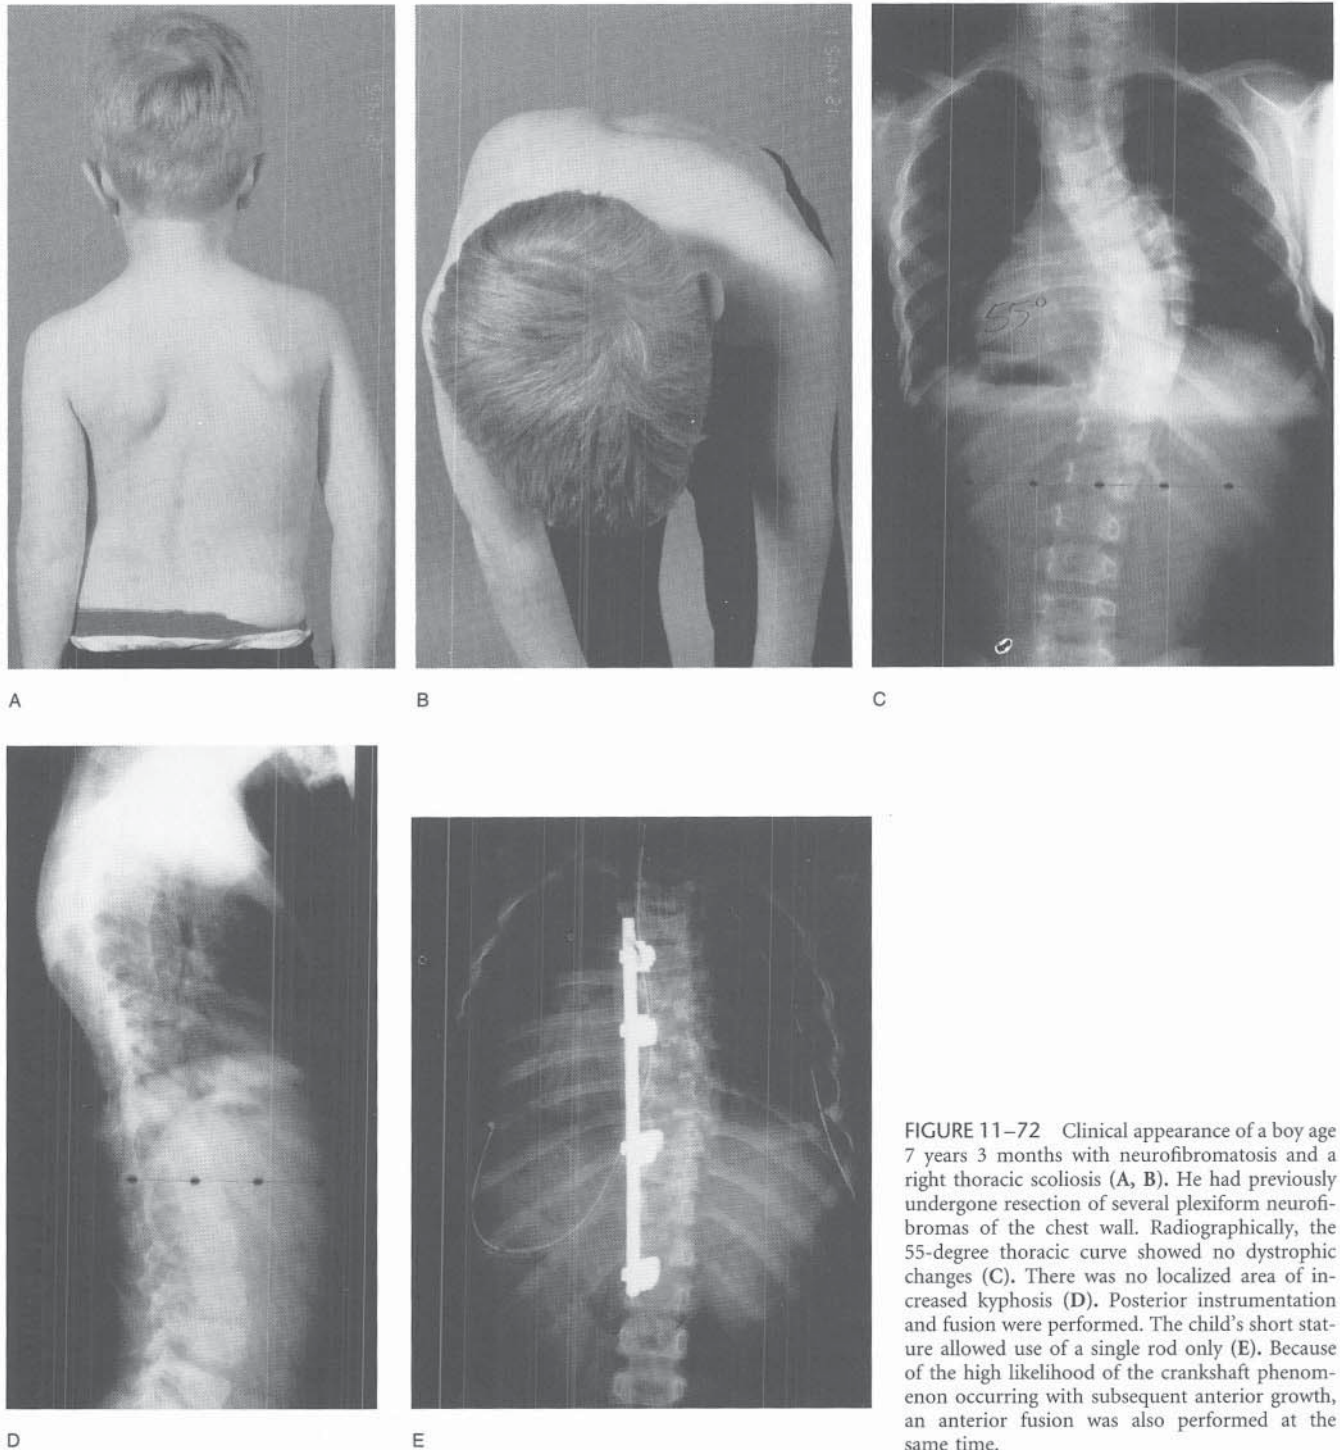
Clinical appearance of a boy age 7 years 3 months with neurofibromatosis and a right thoracic scoliosis (A, B). He had previously undergone resection of several plexiform neurofibromas of the chest wall. Radiographically, the 55-degree thoracic curve showed no dystrophic changes (C). There was no localized area of increased kyphosis (D). Posterior instrumentation and fusion were performed. The child's short stature allowed use of a single rod only (E). Because of the high likelihood of the crankshaft phenomenon occurring with subsequent anterior growth, an anterior fusion was also performed at the same time.
